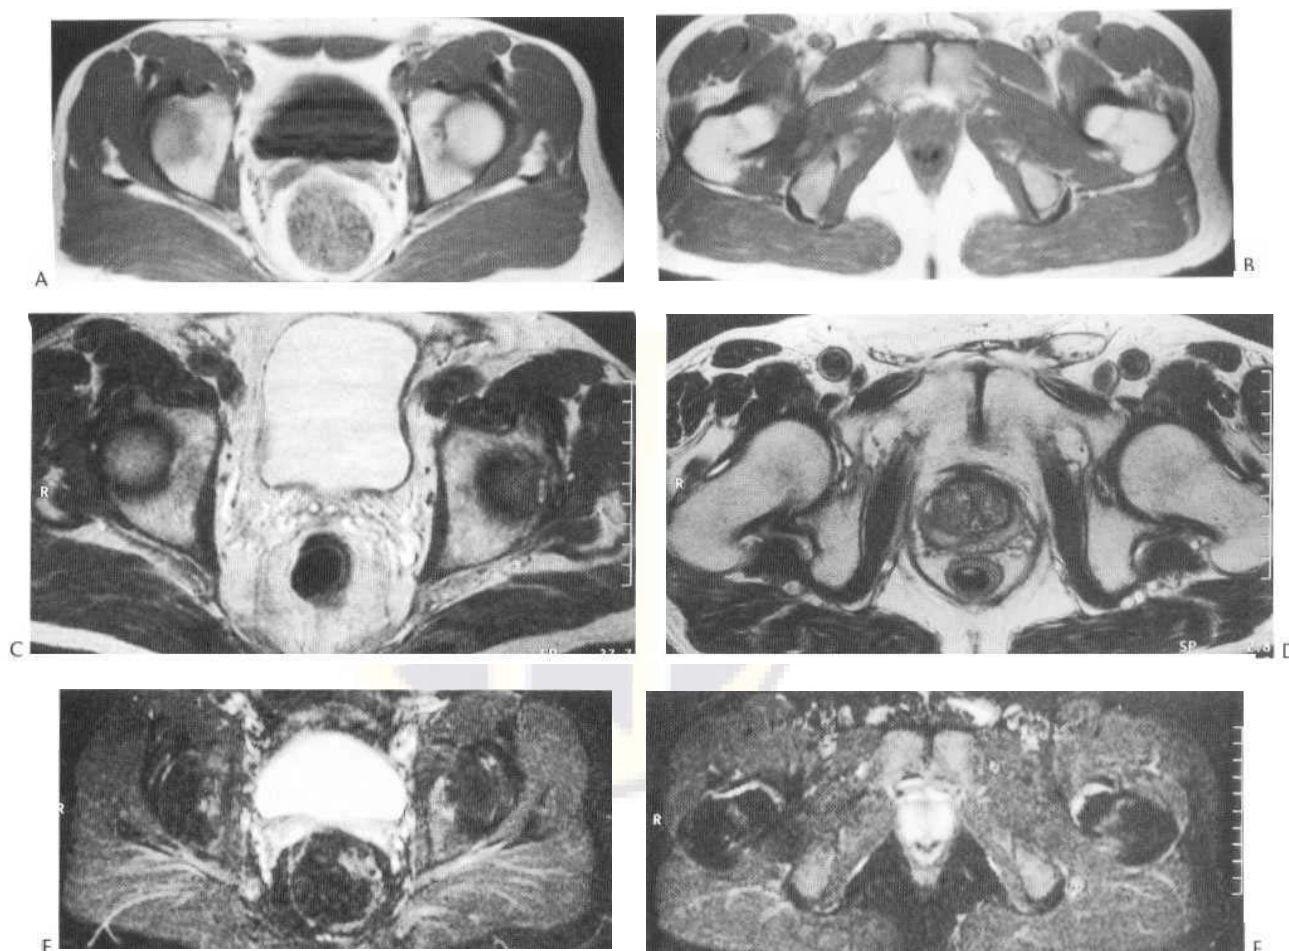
MRI of the pelvis on the T₁-weighted sequence at the level of the bladder (A) and the prostate (B). The same levels (on a different patient) are seen on the T₂-weighted sequence (C,D) demonstrating the increased conspicuity of the bladder wall and the zonal anatomy of the prostate. Both sequences show the puborectalis sling well. The same levels are also shown on the STIR sequences (E, F).
